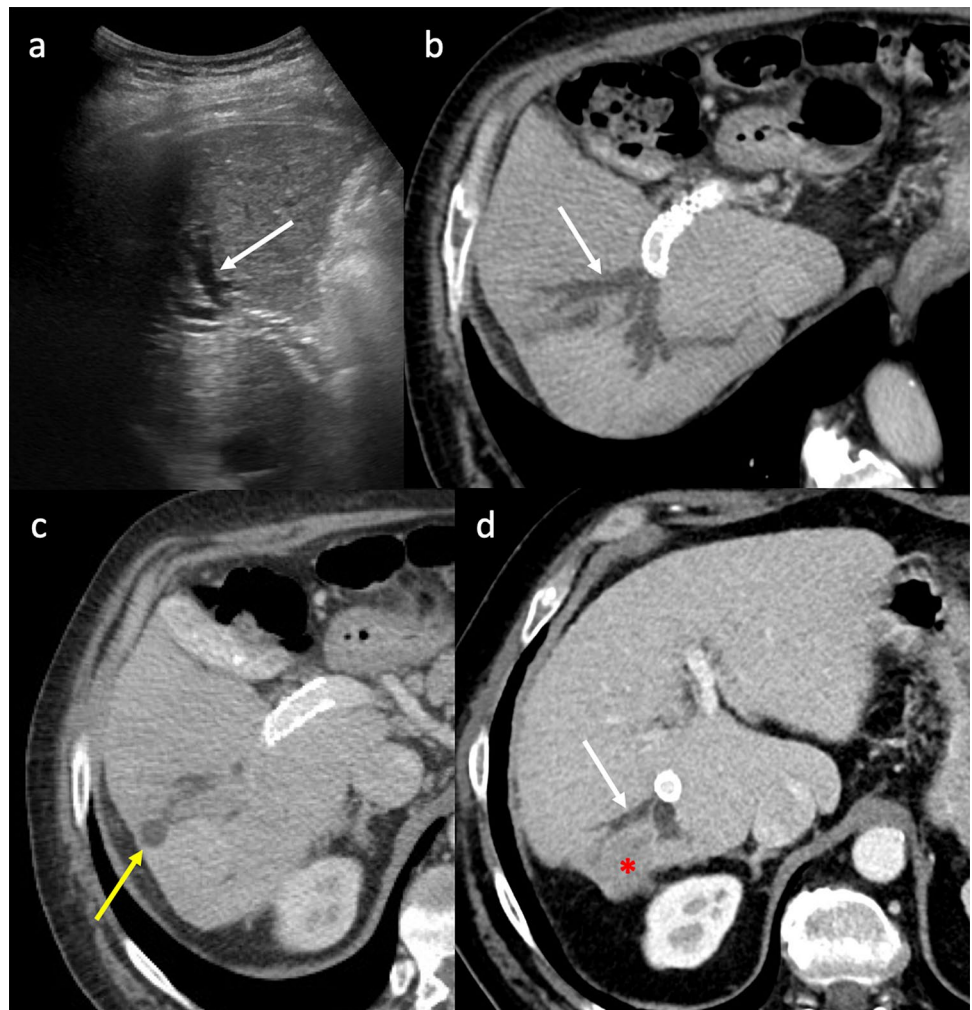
Biliary dilatation and hepatic abscess. Axial unenhanced (a) and contrast-enhanced CT imaging in the arterial (b), portal venous (c), and 3 min late (d) phases show a loculated hepatic abscess (red
